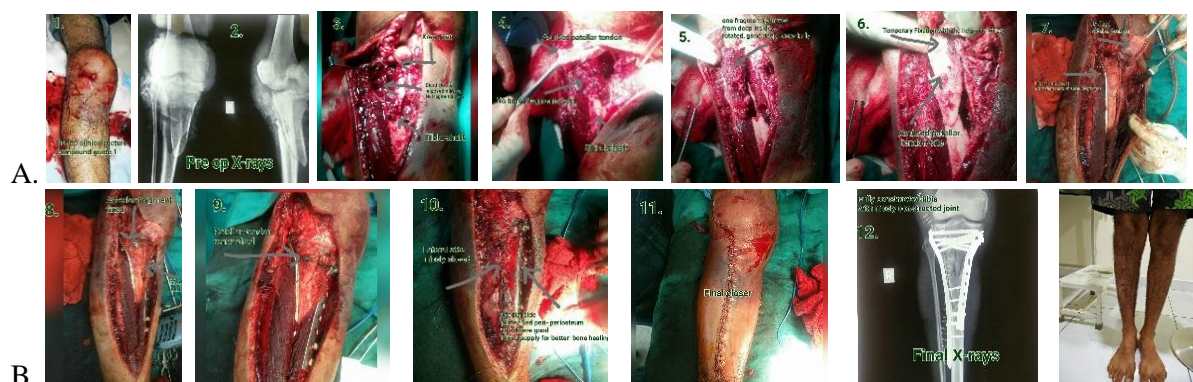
(A, B). A 62 year-old man had a proximal tibial fracture. clinical appearance, diagnostic x-rays and surgical steps-open reduction and open double plating with DCP plates with excellent final clinical outcome. (Courtesy sir R.Tanga)
